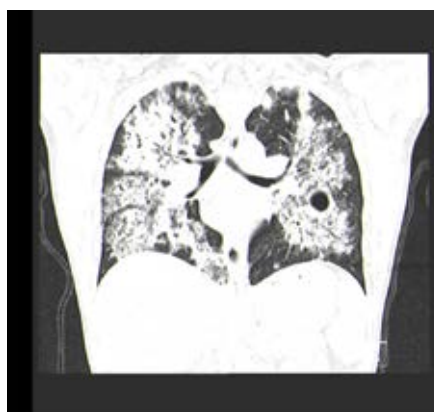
Images from the HRCT chest showing diffuse interstitial and alveolar consolidation, cavities
